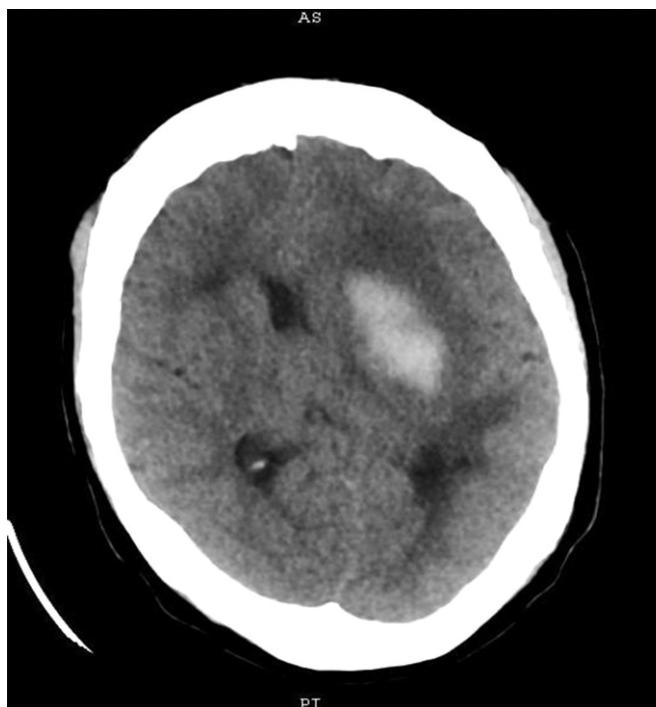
Axial non-contrast enhanced computed tomographic image showing a hyperdense area with surrounding area of hypodensity due to perilesional oedema at the region of left lenticular nucleus and internal capsule with ipsilateral mass effect as evidenced by shifting of midline to the right and compression of left lateral ventricle representing acute intracerebral haemorrhage.
